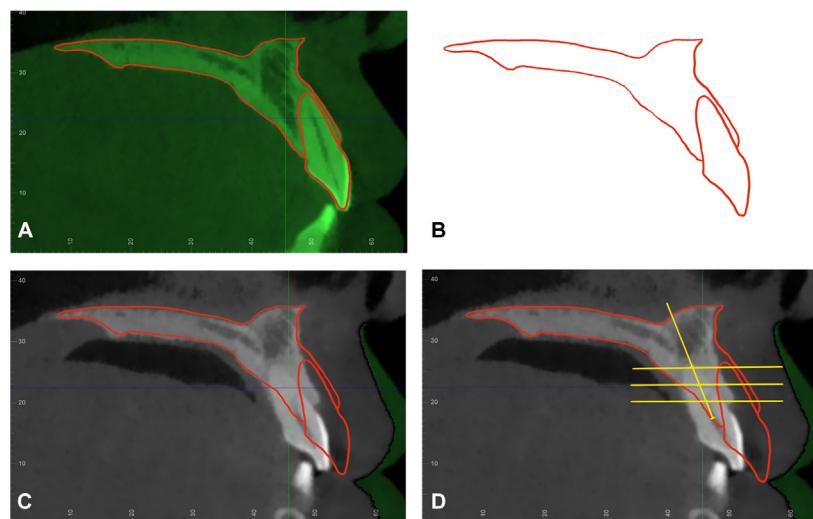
CBCT data processing in Procreate: A, T0 sagittal slice; B, Pretreatment T0 sketch; C, T0 sketch and T1 sagittal slice merged image. D, S1, S2, and S3 level reference lines (*yellow*).
